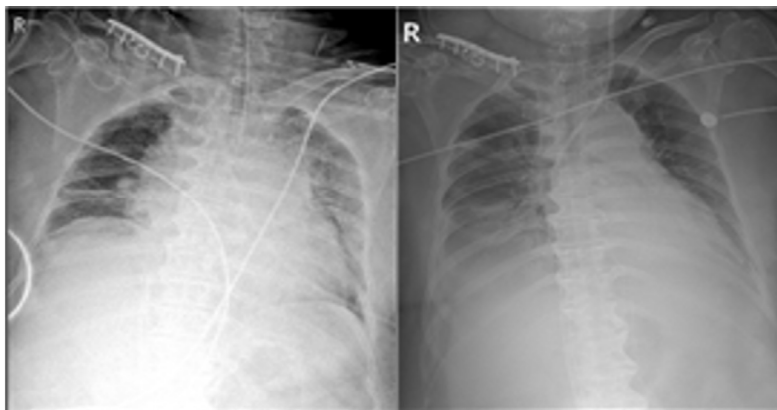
Chest X-ray of patient after catheter thrombus aspiration and heparin, actylase infusion (A), several days after move to intensive care unit (B)
